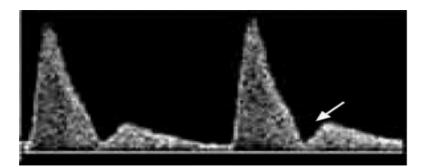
Uterine artery Doppler ultrasound scan showing early diastolic notch (arrow). The presence of diastolic notches is associated with an increased risk of pre-eclampsia and IUGR.
